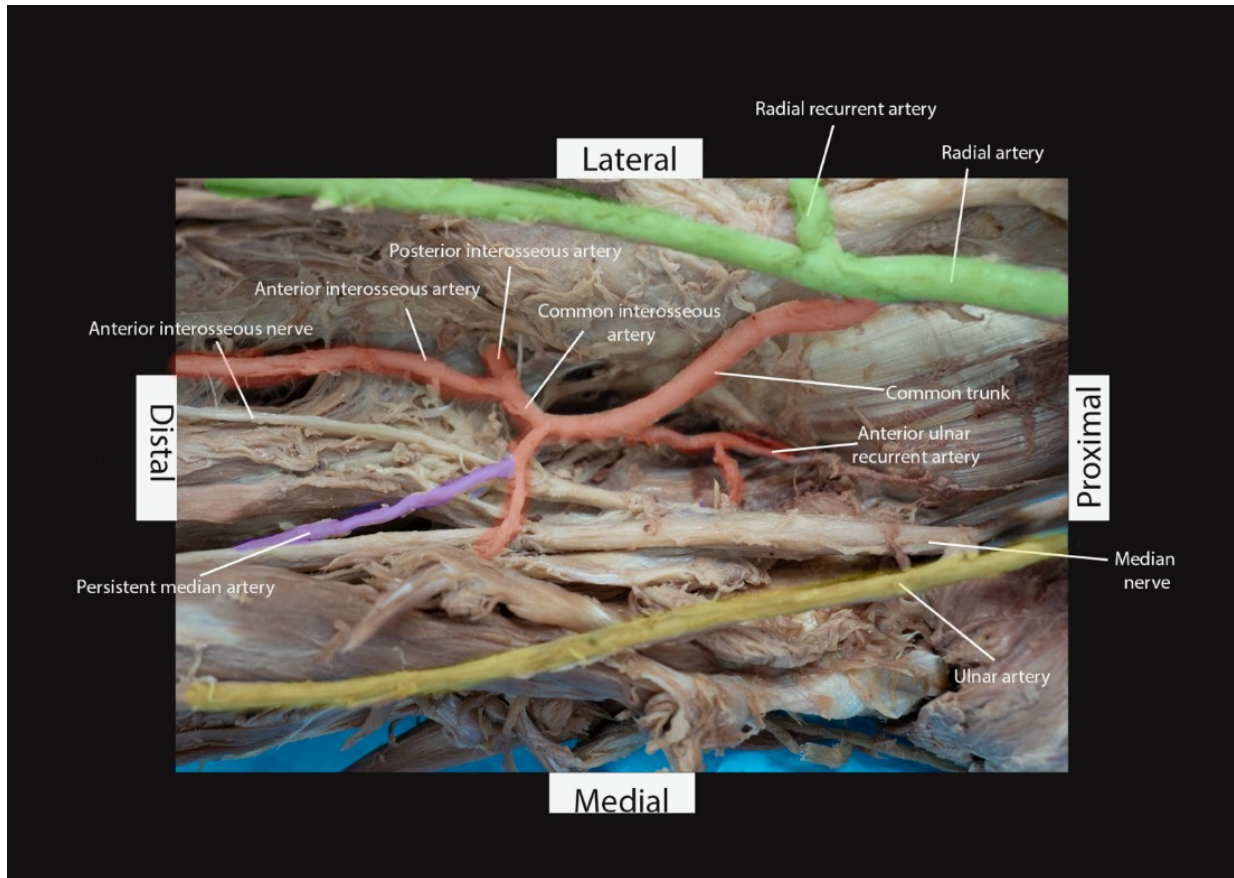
View of the unique branching of the radial artery (green). The CT arises from the radial artery, giving a branch for a common trunk for the anterior and posterior ulnar recurrent arteries. It continues to give the common interosseous artery and the persistent median artery (purple).
